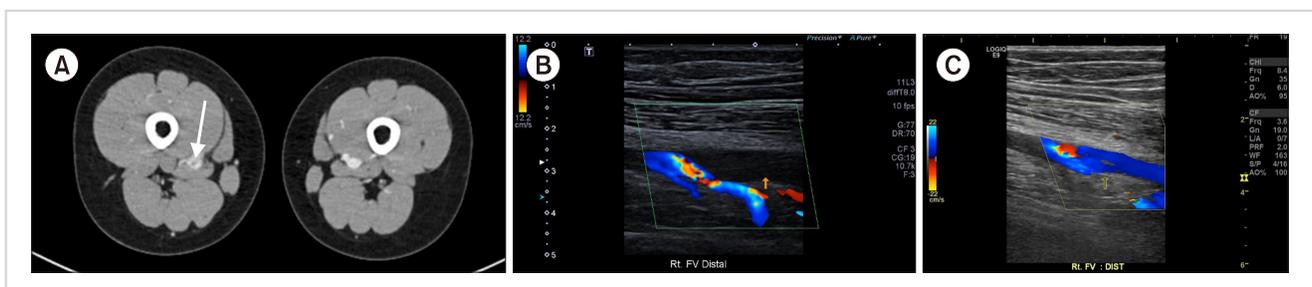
Computed tomography (CT) angiography and venous duplex ultrasound of the lower extremity in a pediatric patient with secondary antiphospholipid syndrome associated with immune thrombocytopenia. (A) In the lower extremity CT, a small focal filling defect (white arrow) was observed at the right distal superficial femoral vein suggesting deep vein thrombosis (DVT). (B) In the venous duplex ultrasound of the lower extremity, occlusion of the branch of right femoral vein and collateral veins was observed. (C) After 3 months of anticoagulation, follow-up duplex ultrasound showed improvement of DVT.
